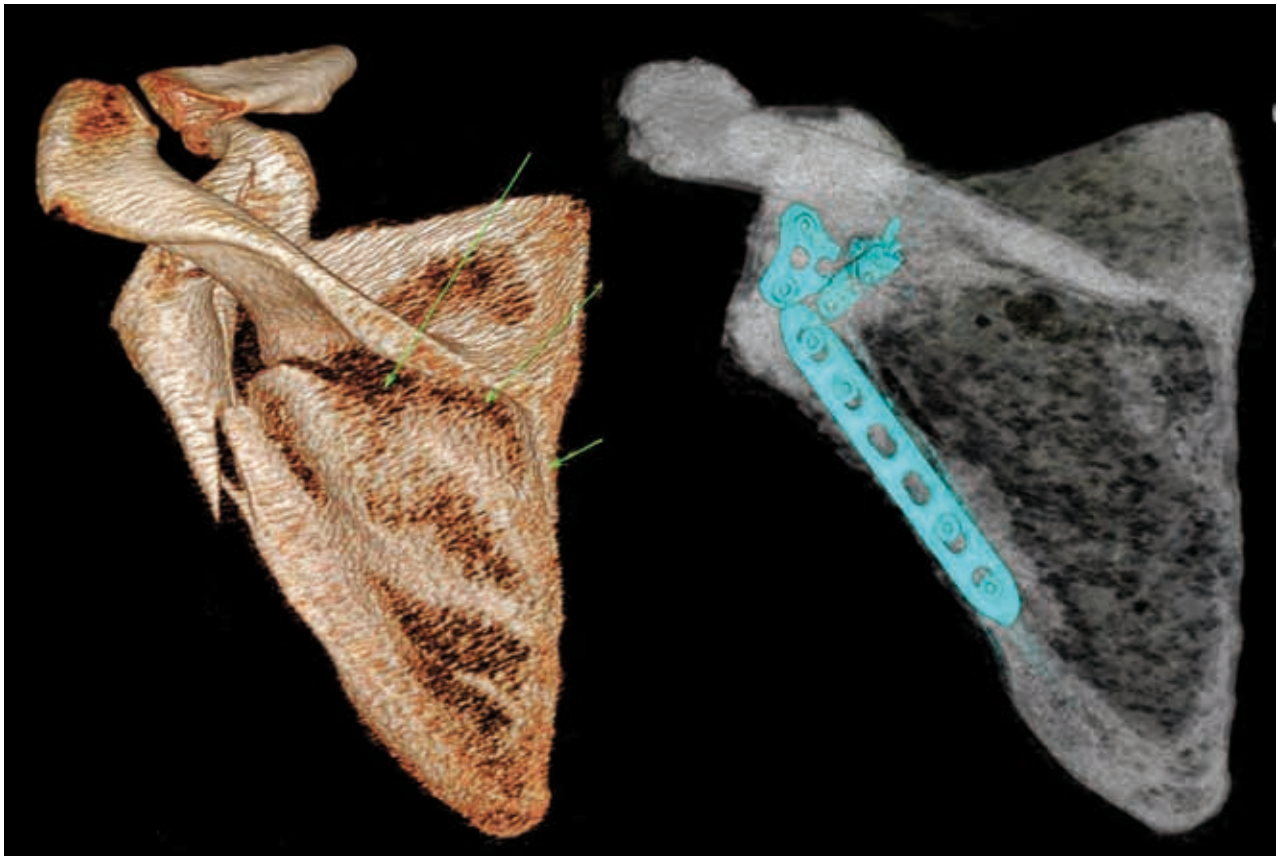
The 2-year outcome of operation on comparative pre- and postoperative 3D CT reconstructions of the scapula. Green arrows show the course of the fracture line to the spinomedial angle.
